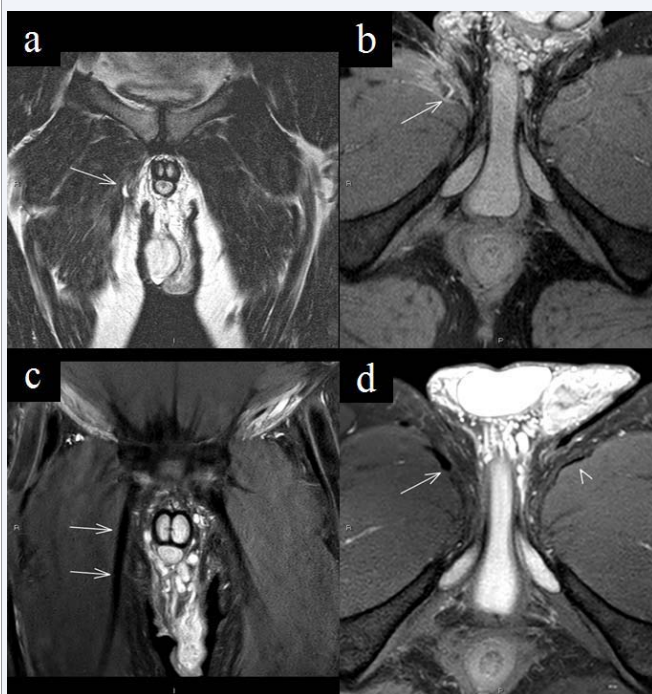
A transverse tenotomy was made on the right affected adductor longus tendon approximately 4 cm distal to the origin of the tendon (arrows, images a and b). The tenotomy had healed completely at the 1-year postoperative MRI (arrows, images c, d). Only a minor thickening of the tendon (arrow, d) is seen when comparing to the unaffected left side (arrowhead, d).
